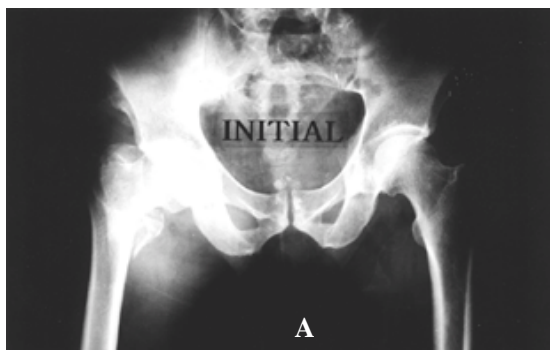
Serial radiographs of 70 year-old man treated with a compression hip screw.
